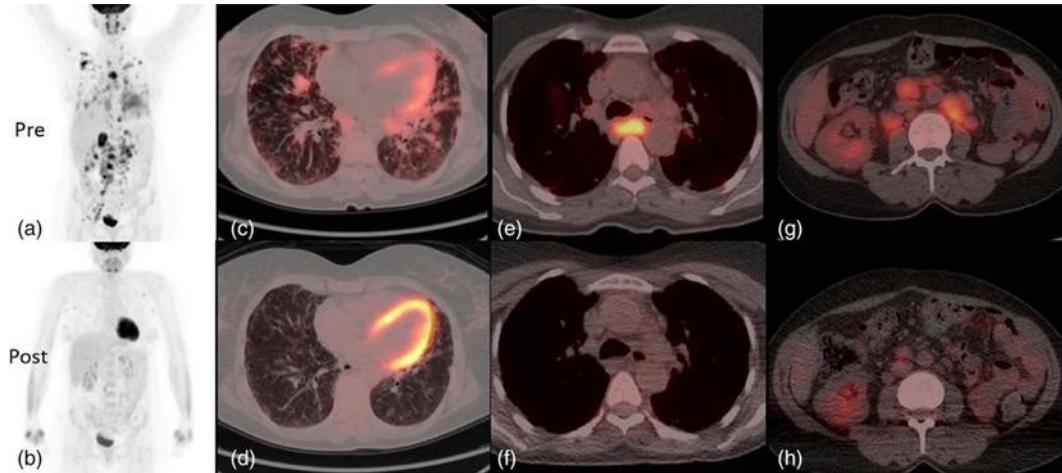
2-[[18F]-fluoro-2-deoxy-d-glucose positron emission tomography and computed tomography (FDG PET-CT) pre- and 3 months post- specific GLILD immunosuppressive treatment with rituximab and mycophenolate⁶⁰.
